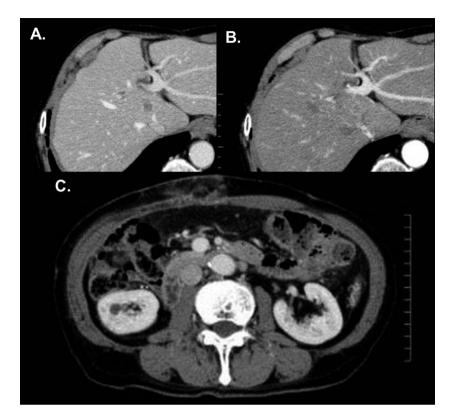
Preoperative CT findings. (A) Contrast-enhanced CT revealed a relatively well-circumscribed mass (15 mm in diameter) in segment 1 of the liver. (B) The tumor displayed an enhancement in the late phase of contrast-enhanced CT. (C) A swollen lymph node around the abdominal aorta.
